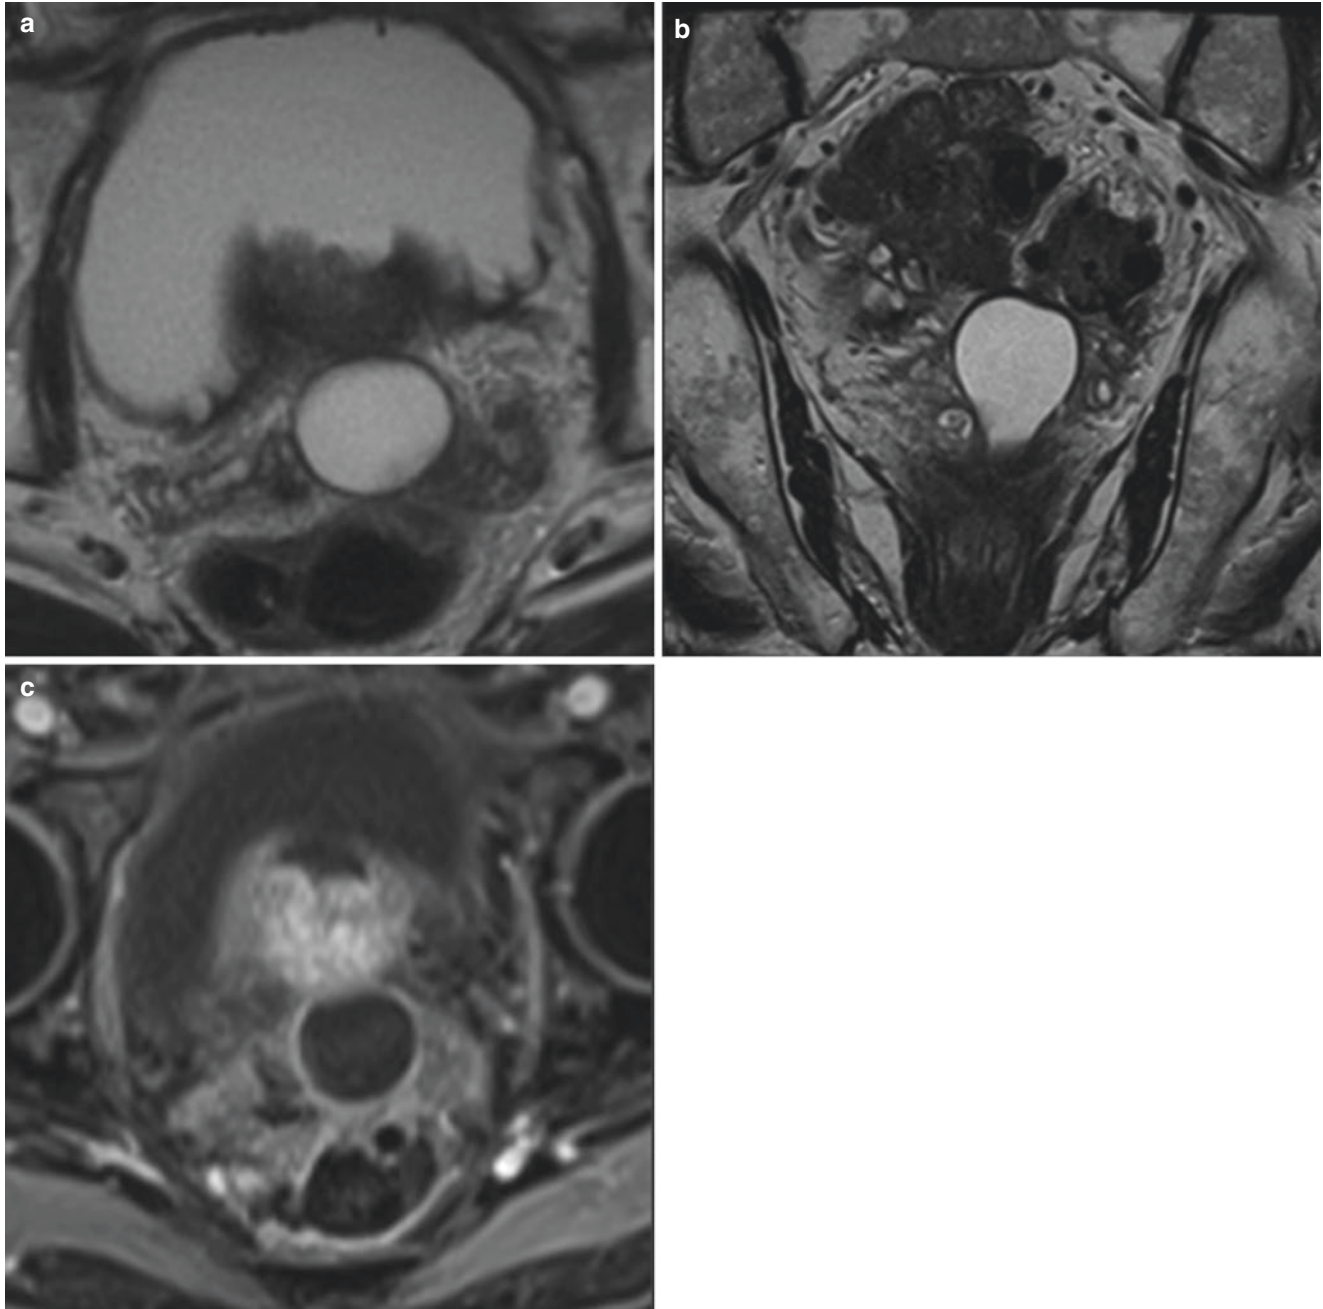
Prostatic Müllerian duct cyst in a 32-year-old man with lower urinary tract symptoms. Axial (a), coronal (b) T2-weighted MR images, and axial (c) contrast-enhanced fat-suppressed T1-weight MR
